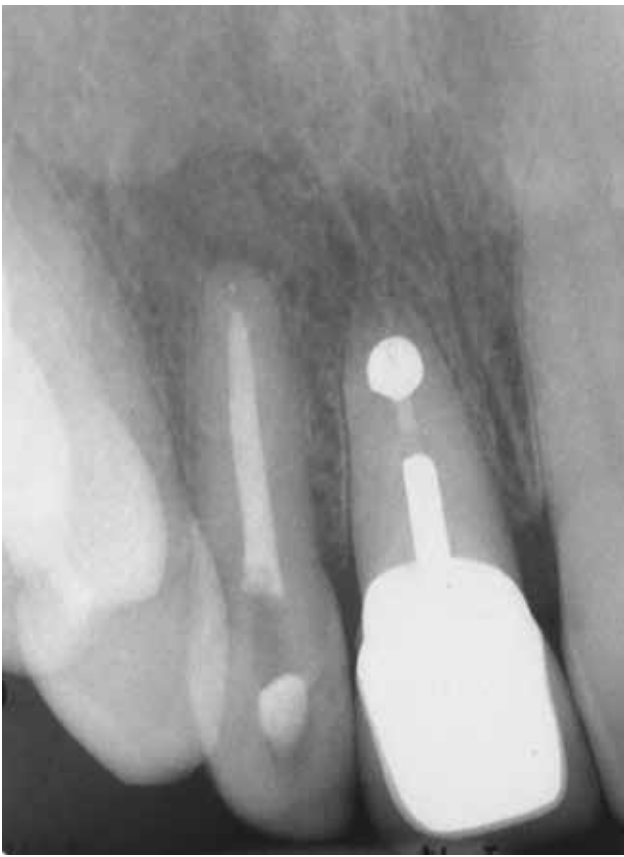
Periapical of #7 and #8.
